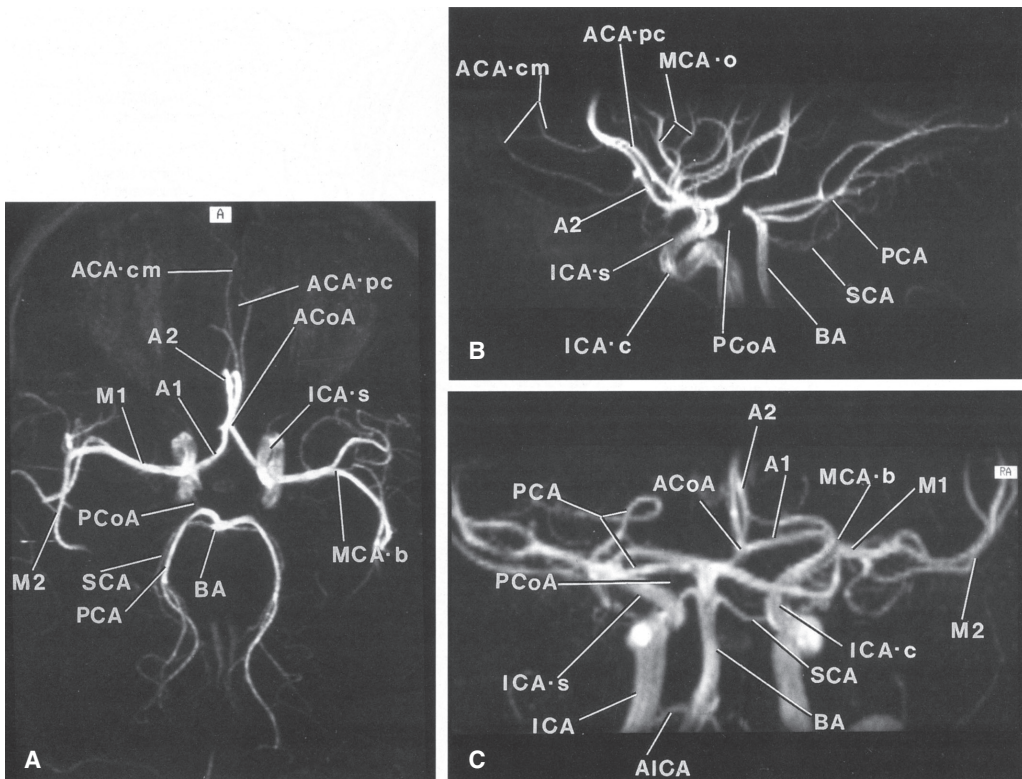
Arterial anatomy of a magnetic resonance section: axial (A), sagittal (B, C), and coronal (C). *ACAcm* = anterior cerebral artery, callosal marginal branch; A2 and A1 are branches of the anterior cerebral artery; *ACApc* = pericallosal branch of the anterior cerebral artery; *ACoA* = anterior communicating artery; M1 and M2 are segments of the middle cerebral artery (*MCA*); *MCAb* = bifurcation; *ICAs* = internal carotid artery siphon; *PAC* = posterior cerebral artery; *PCoA* = posterior communicating artery; *BA* = basilar artery; and *SCA* = superior cerebellar artery. (Modified from Grossman CB. *Magnetic Resonance Imaging and Computed Tomography of the Head and Spine*. 2nd ed. Philadelphia, PA: Williams & Wilkins; 1996:124.)
